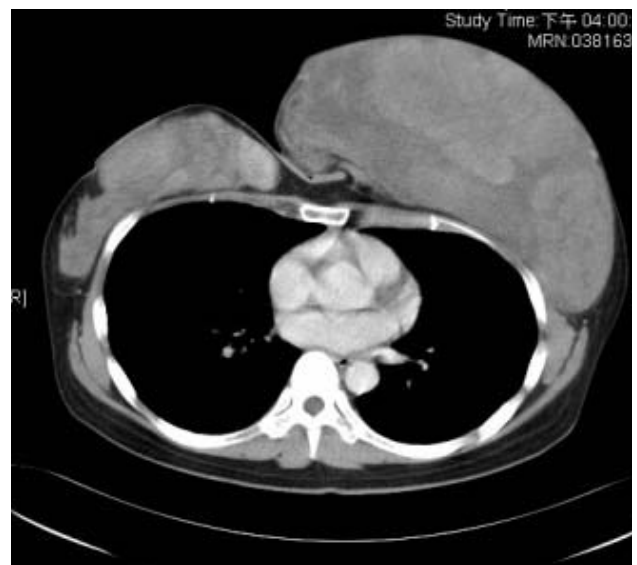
The left breast is polylobulated on post-contrast CT.
